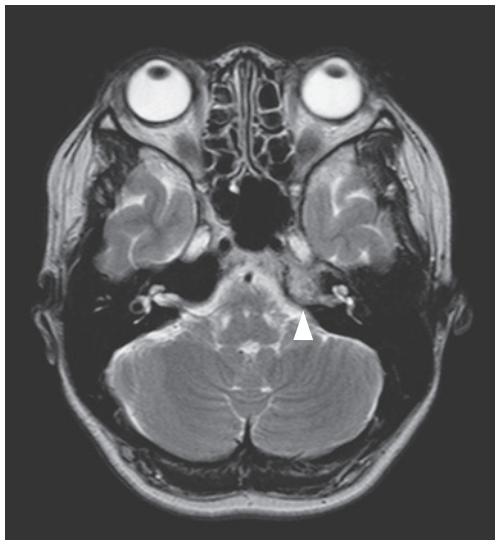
T2-weighted MR image
